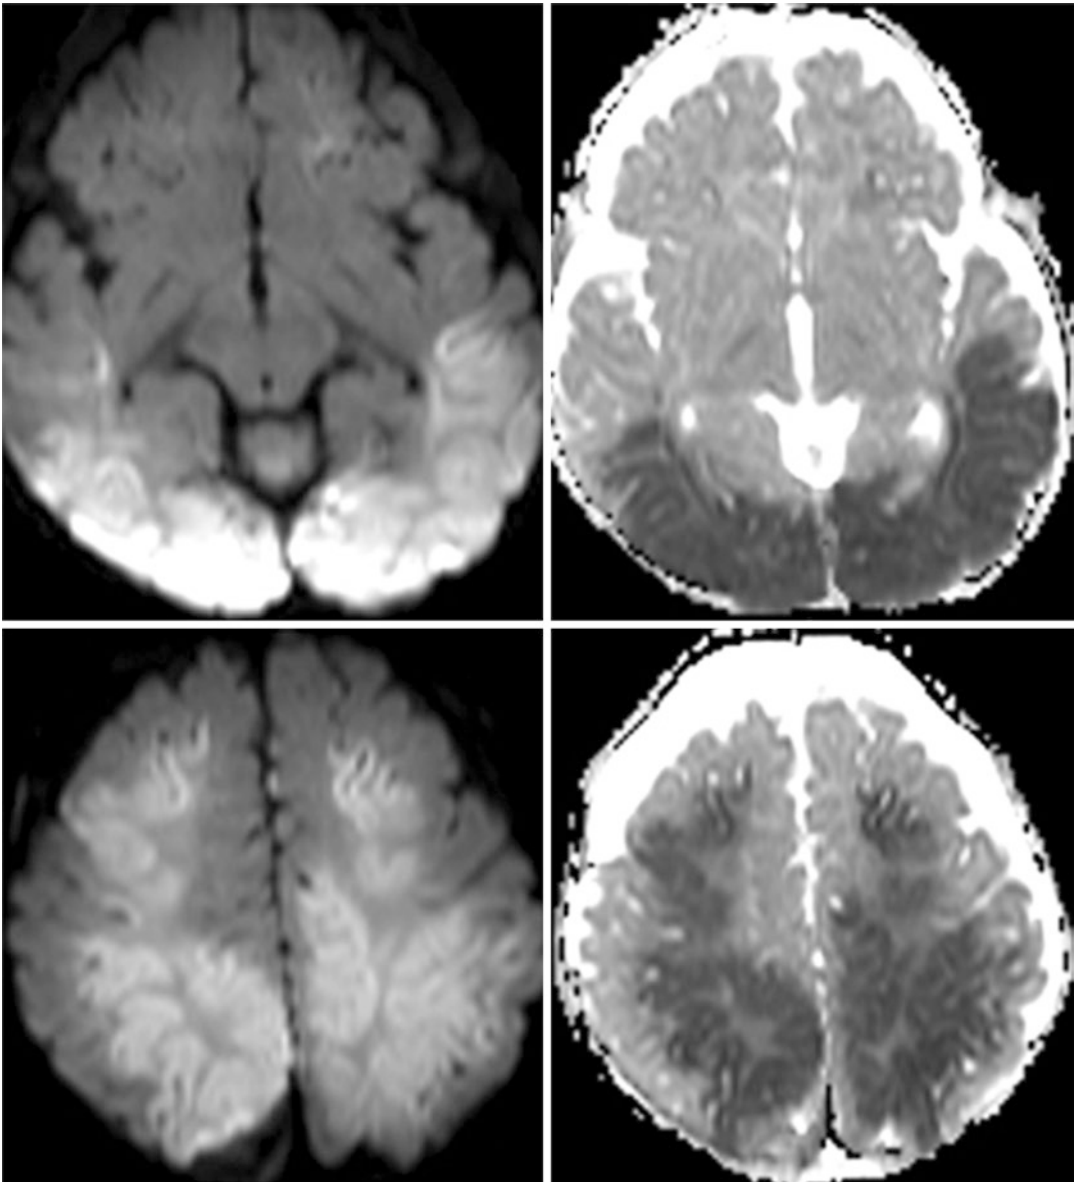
Axial DWI sequences. These is extensive bilateral symmetrical diffusion restriction within the cerebral hemispheres are in keeping with an acute hypoxic-ischaemic insult
